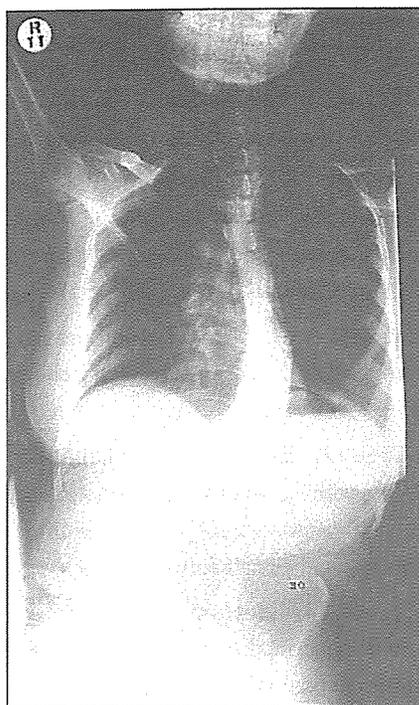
a,b. Preoperative X-rays demonstrate trunk imbalance.
